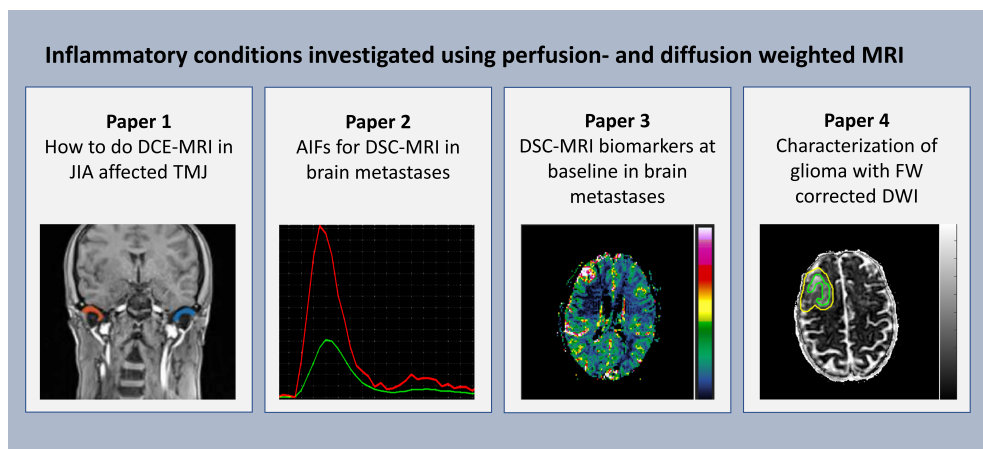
Paper 1 investigates acquisition parameters in dynamic contrast enhanced (DCE)-MRI of the temporomandibular joint (TMJ) with possible involvement of juvenile idiopathic arthritis (JIA). Paper 2 investigates choices of arterial input functions (AIFs) in dynamic susceptibility contrast (DSC)-MRI in brain metastases. Paper 3 investigates DSC-MRI perfusion parameters in relation to outcome after stereotactic radiosurgery in brain metastases. Paper 4 applies free water (FW) corrected diffusion MRI to characterise glioma.
